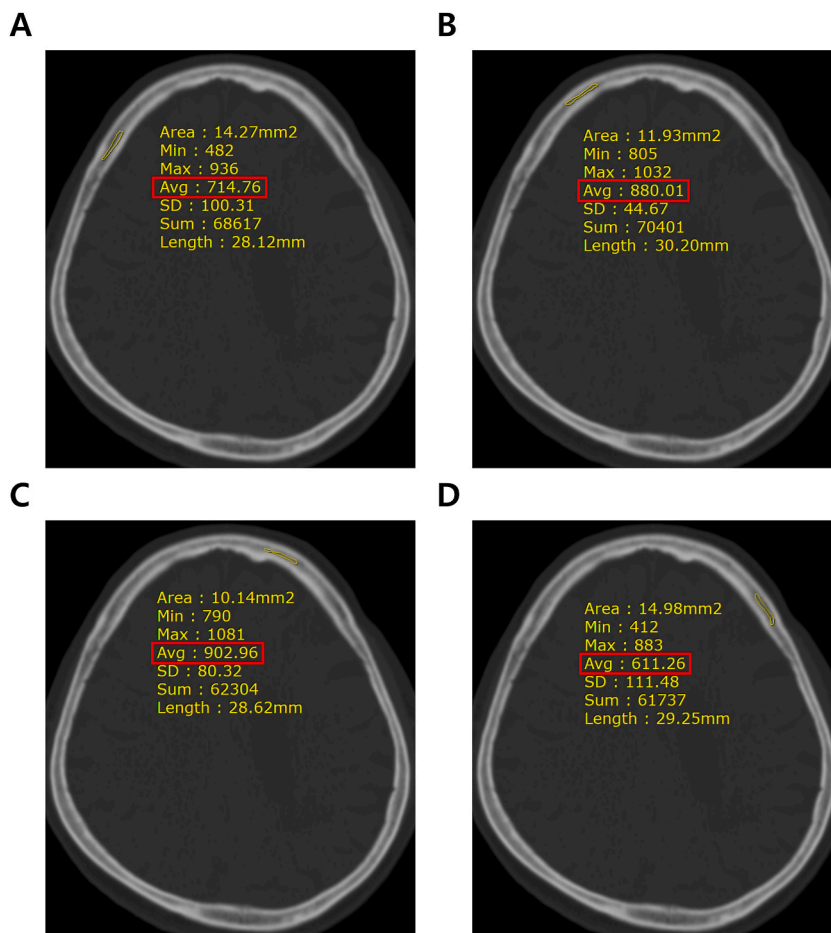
The process involves the PACS system automatically determining the maximum, minimum, and average HU values across four specific areas of cancellous bone in the frontal skull on brain CT scans. (A) Right lateral; (B) right medial; (C) left medial; (D) left lateral. HU, Hounsfield unit; PACS, picture archiving and communication system.
